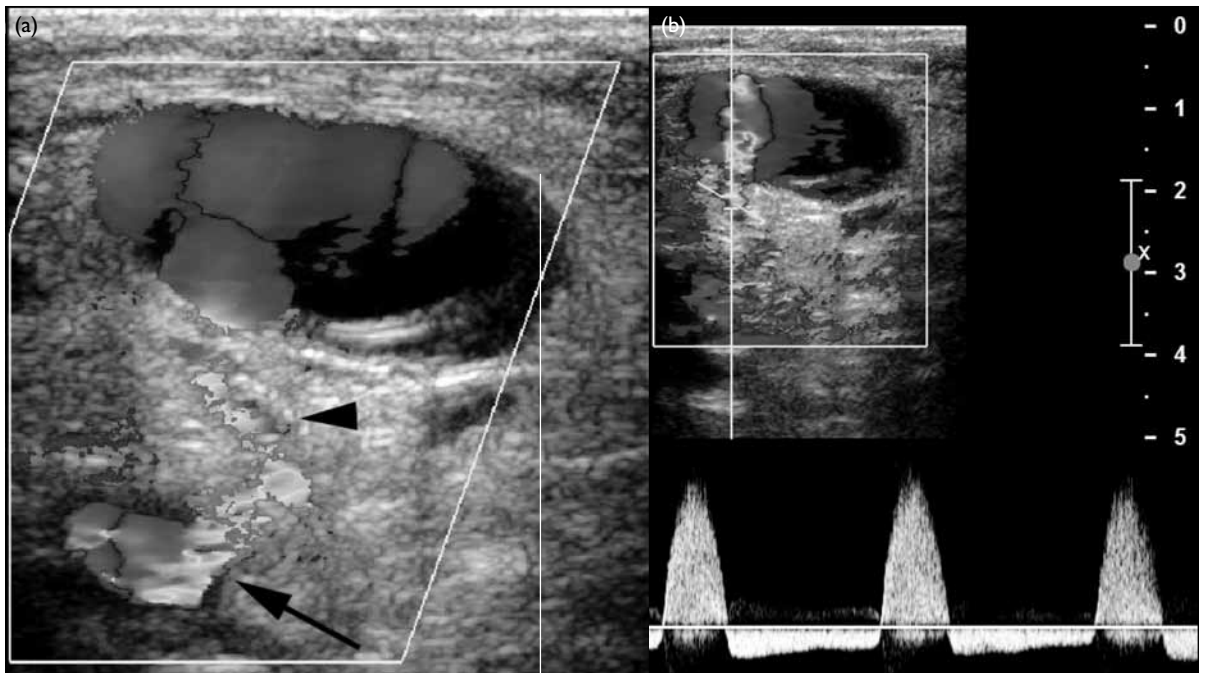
(a) Doppler ultrasound of a 74-year-old man (patient No. 1) who had recently undergone percutaneous coronary intervention. Transverse image of the right groin shows a large pseudoaneurysm demonstrating a “yin-yang” appearance on colour Doppler due to swirling turbulent blood flow. Note the ‘neck’ of the aneurysm (arrowhead) which shows communication with the right common femoral artery (arrow). (b) Doppler waveform at the neck shows ‘to-and-fro’ flow pattern, with blood in-flow during systole and out-flow during diastole
